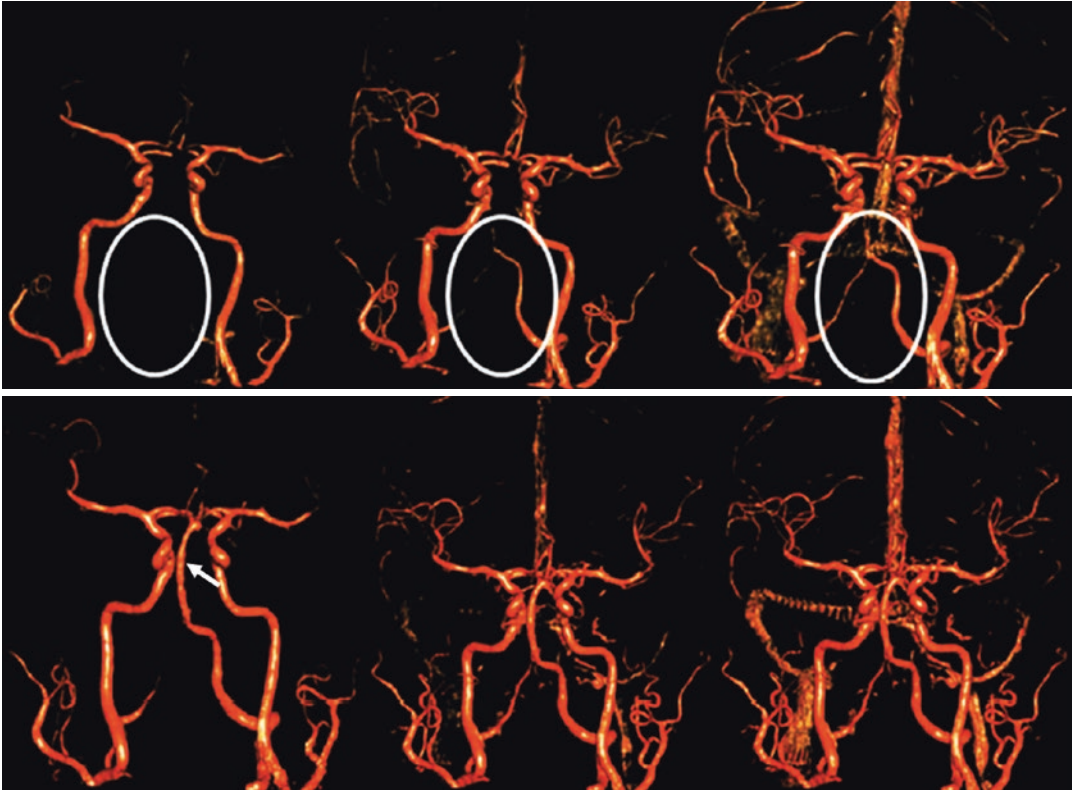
Time-resolved CBCTA images before (top row) and after endovascular treatment of an acute ischemic stroke. There is an occlusion of the basilar artery
